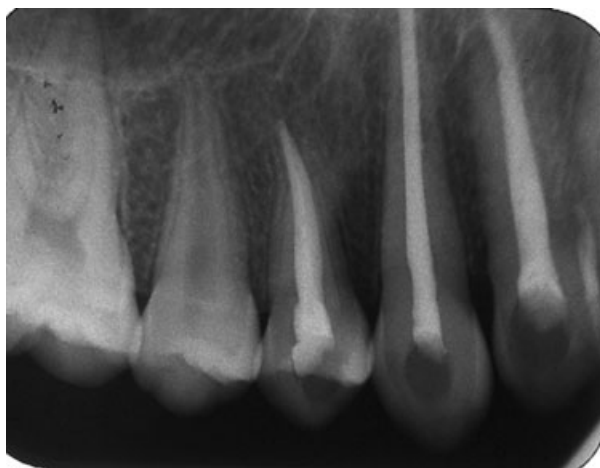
Radiographic view 1 month later.
